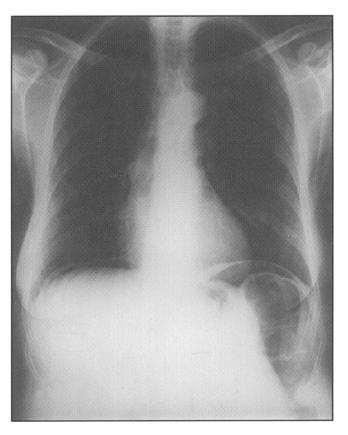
Plain X-ray 6 days later demonstrating spontaneous resorption of the pneumoperitoneum.
